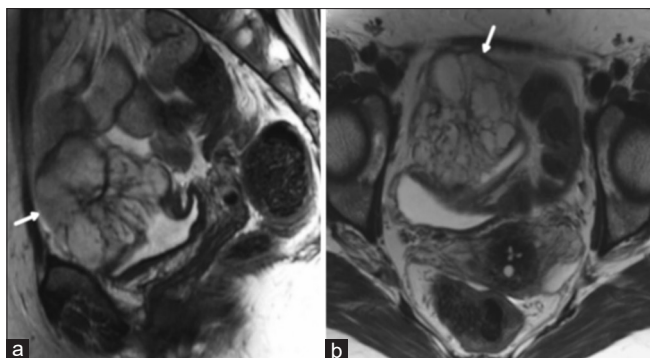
Sagittal (a) and axial (b) T2 weighted magnetic resonance imaging of the pelvis demonstrating a lobulated supravescical lesion (arrows) with heterogeneous hyperintense signal abnormality representing mucin
